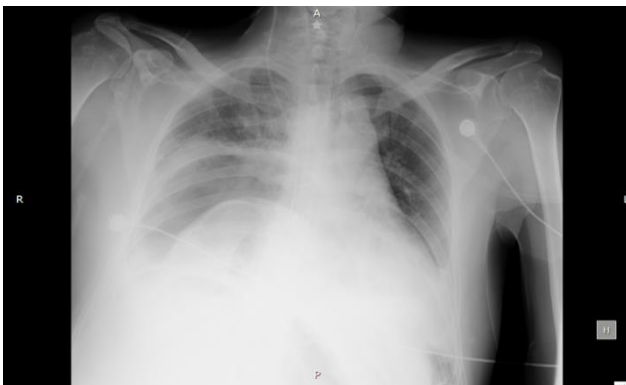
Chest X-ray, gastric bubble is observed in right side.
